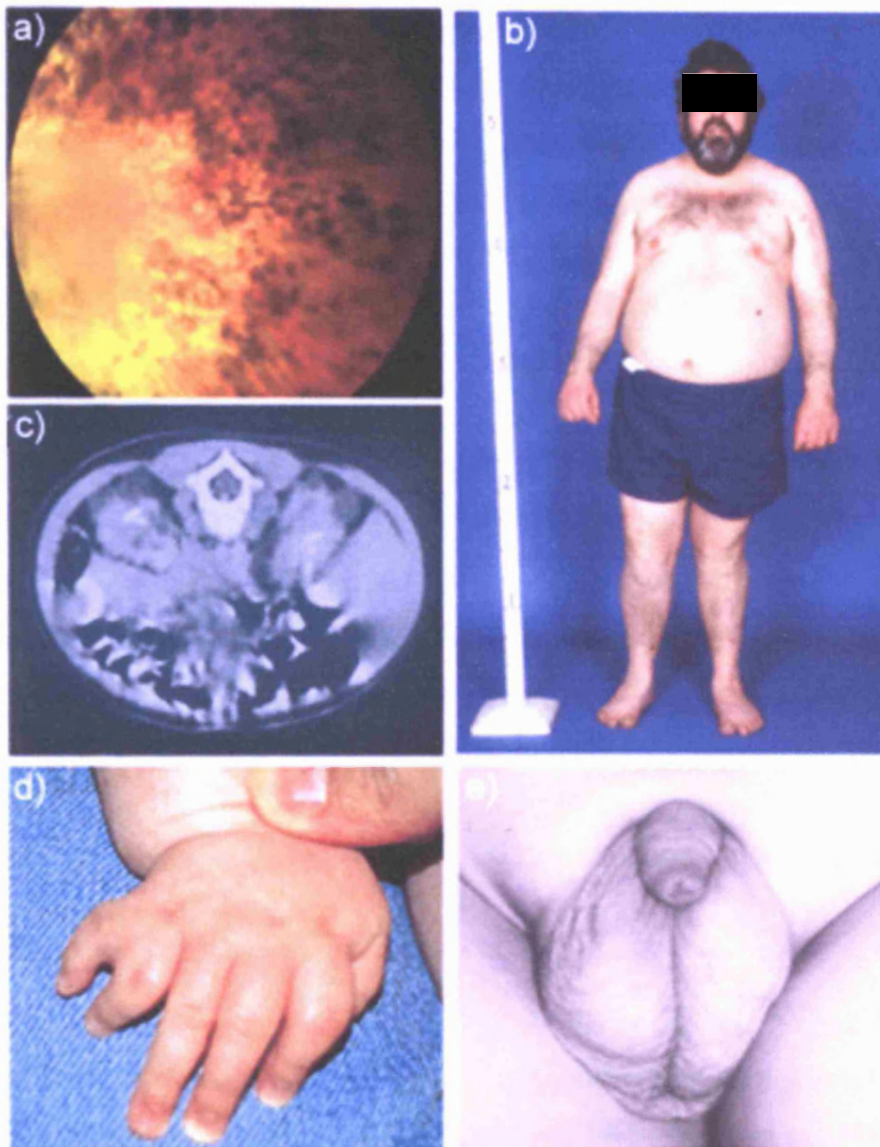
1: Primary features of BBS. a) Fundoscopy from a 32 year old patient showing rod-cone dystrophy. b) Truncal obesity. c) Abdominal CT scan of an 11-year-old patient, showing irregular shaped kidneys with multiple cysts. d) Postaxial polydactyly of the hand. e) Hypogonadism.
